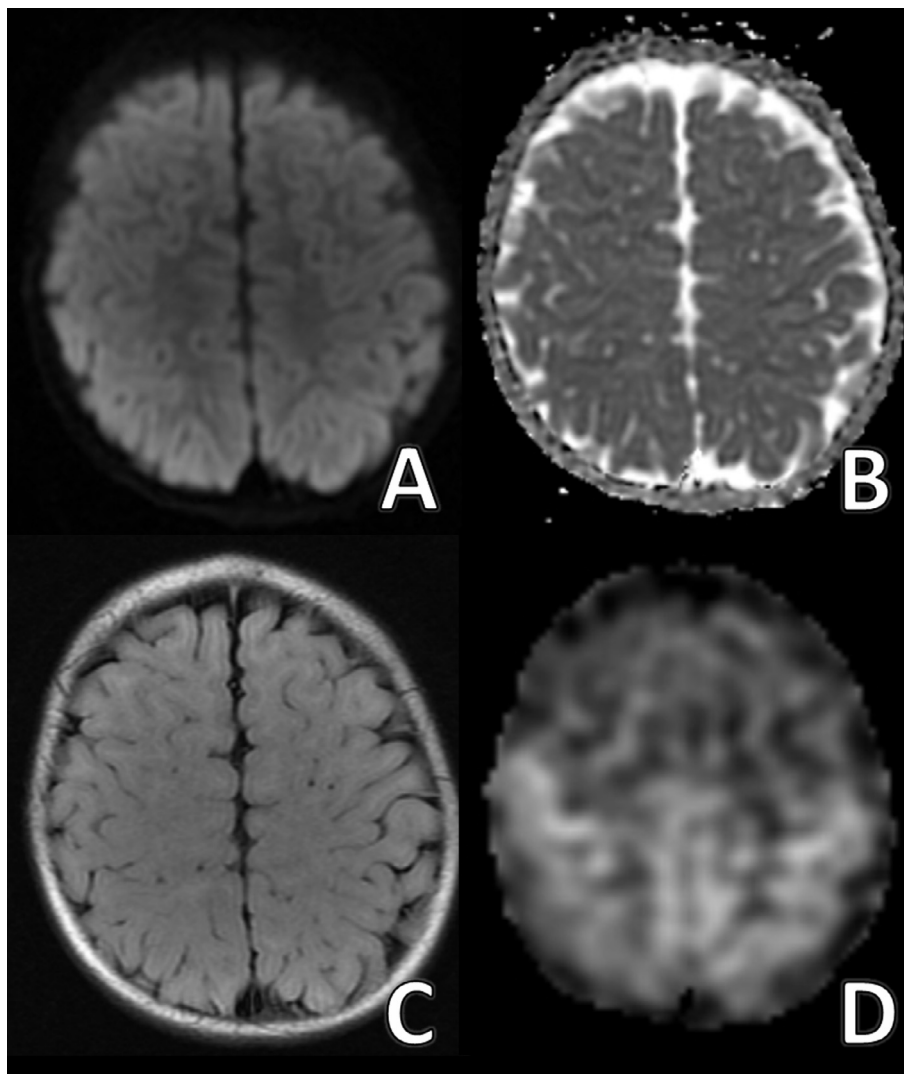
MRI on the day of admission. No abnormal findings are observed on conventional sequences such as DWI (A), ADC mapping (B), and FLAIR (C). In contrast, markedly reduced CBF is observed in bilateral frontal lobes on ASL (D).
